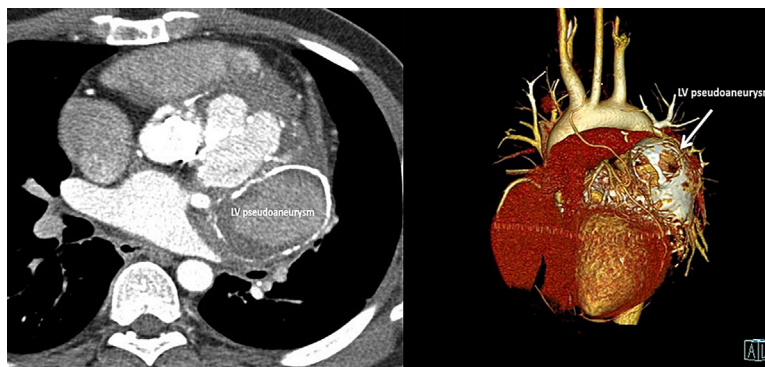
Contrast-enhanced multislice computed tomography in transverse section demonstrating left ventricular outflow tract pseudoaneurysm 8–10 cm in diameter (A) and 3D reconstruction (B) showing the left ventricular pseudoaneurysm from anterolateral angle (arrow). LV, left ventricle.
